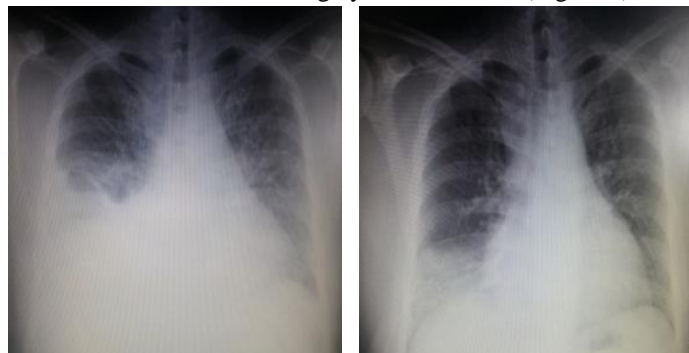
Chest X-ray images of the patient on the 1st day (left image) and after the treatment; on the 12th day (right image)
